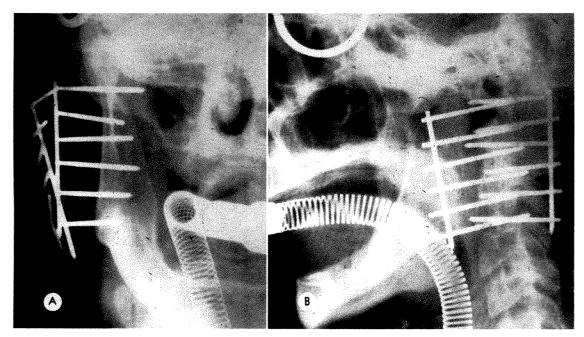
V-plane radium needle implant to parotid gland. (A) Anteroposterior and (B) lateral roentgenograms.
